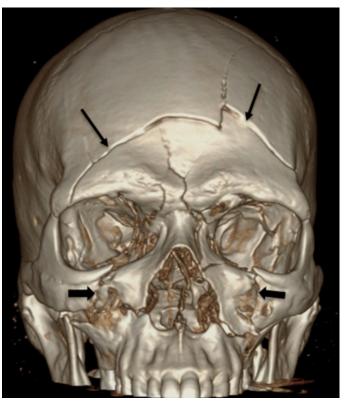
3D CT scan of facial bones coronal view showing fractures of frontal bones (long black arrows), orbital roofs, orbital floors, maxillary sinuses (short black arrows), nasal septum and nasal bridge.
